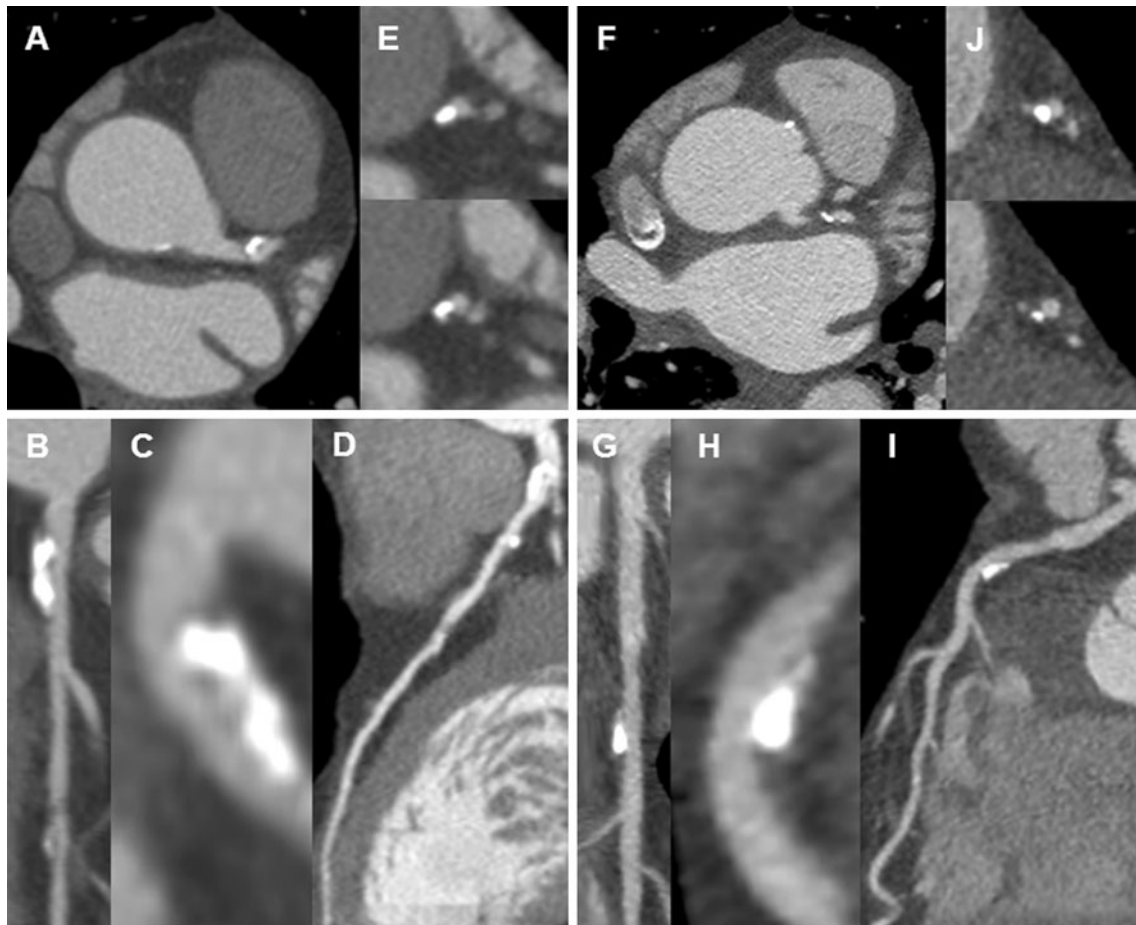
Two matched patients (SDCT: HR 58 ± 0.7 bpm, BMI 24.0 kg/m^2 ; HDCT: HR 58 ± 0.9 bpm, BMI 24.0 kg/m^2) with almost identical image quality (1.73 in SDCT and 1.75 in HDCT scan) and effective radiation dose (SDCT: 1.66 mSv; HDCT: 1.51 mSv). Standard-definition CT (a–e) and high-definition CT (f–j) images of the heart. Axial images of the heart (a, f), multi planar reconstructions
